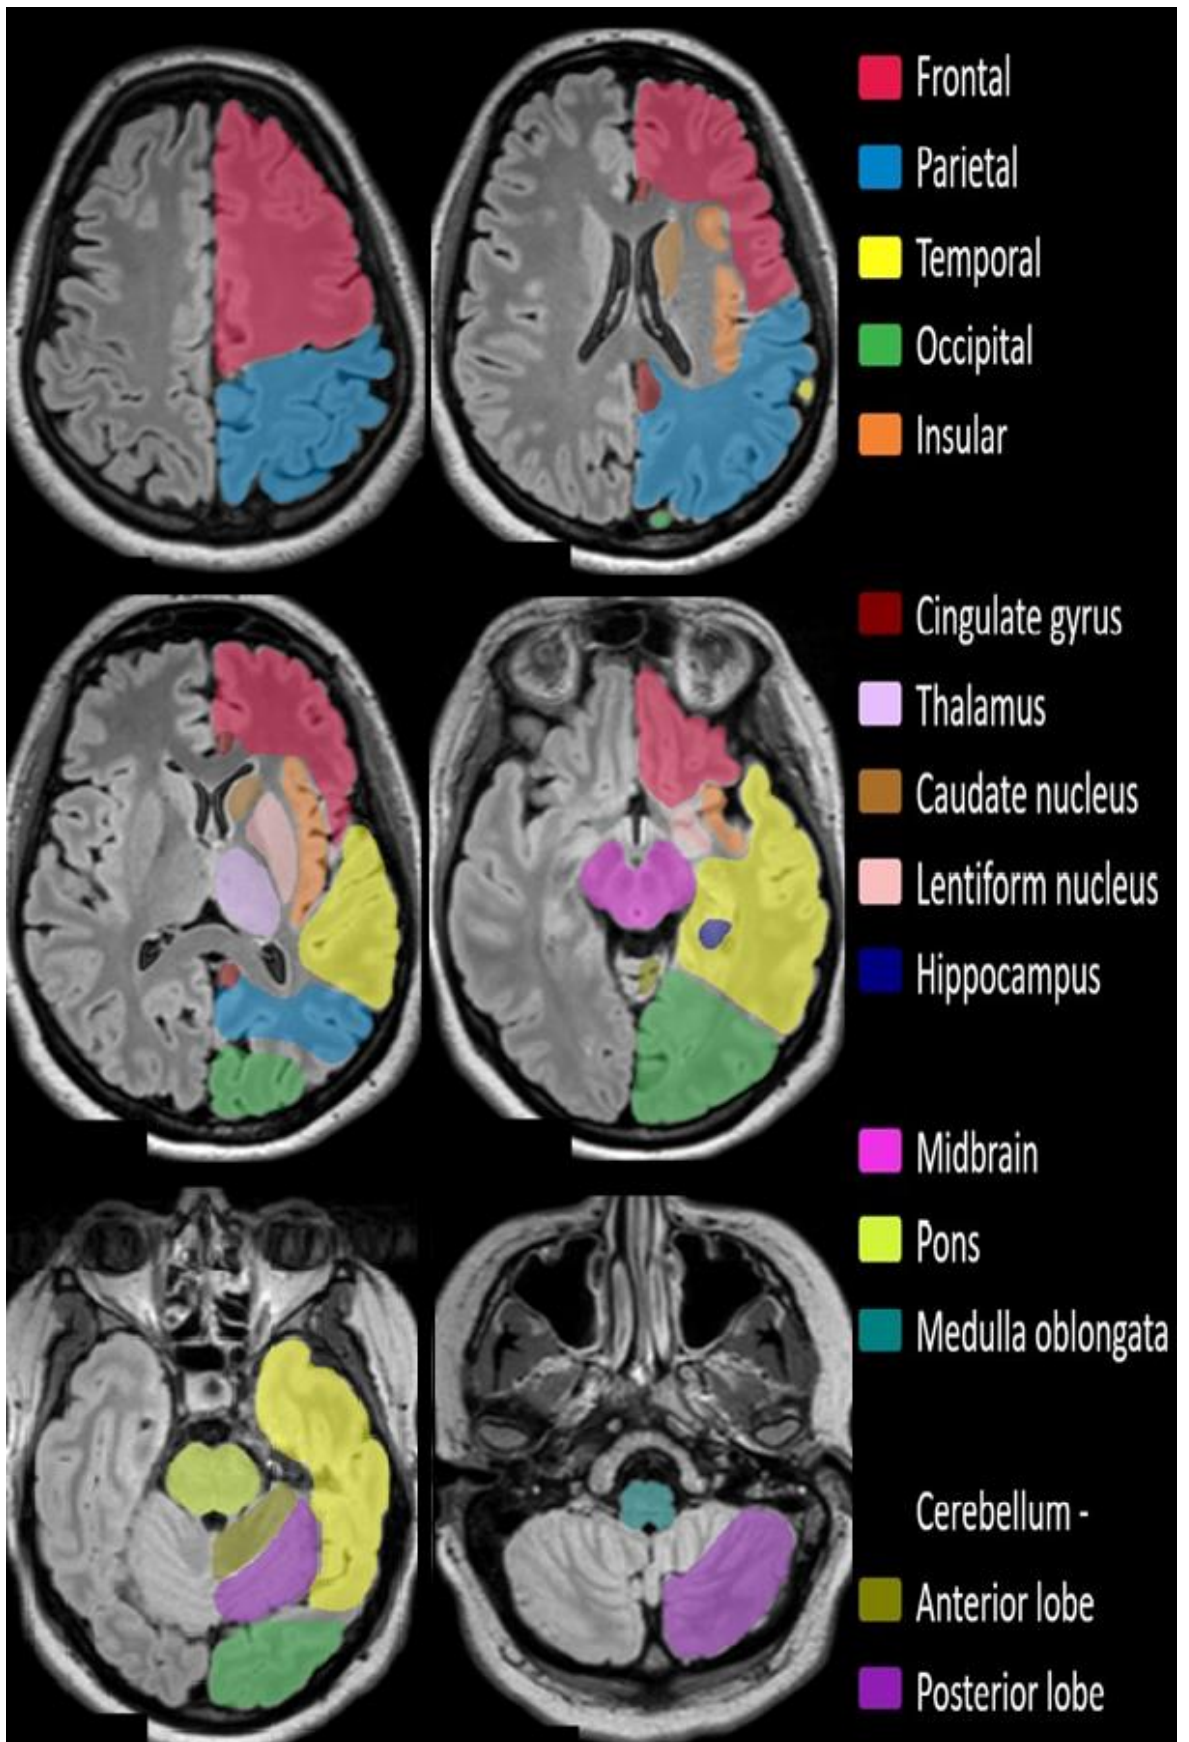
T1-weighted MRI of a healthy volunteer demonstrating anatomical location of the intracranial structures in relation to the hippocampus. Case courtesy of Maciej Debowski, Radiopaedia.org, rID: 61691 (Debowski M, 2018)
